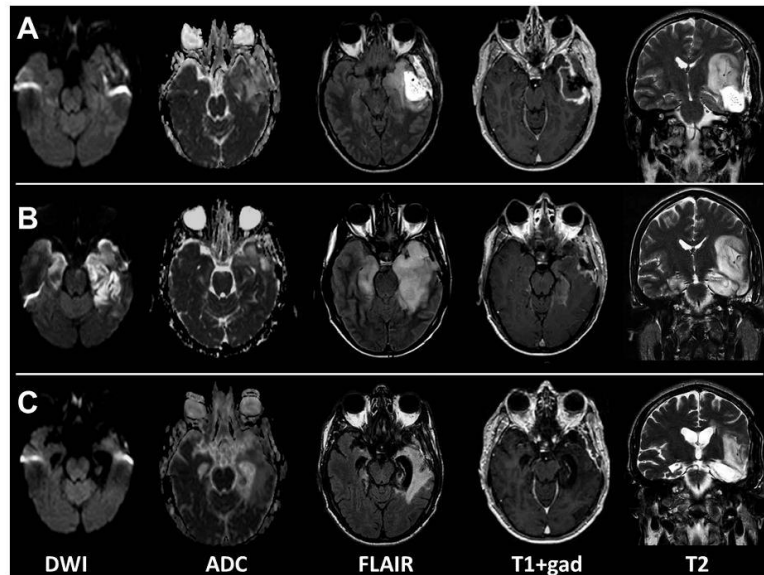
Patient 2 MRI pattern. (A) 22 days after surgical resection in the lateral left temporal lobe, with residual anaplastic astrocytoma in the left insula. (B) During acute herpes simplex encephalitis (HSE), involving bilateral temporomesial structures, more in the left hemisphere, where diffusion restriction and contrast enhancement is also more evident. (C) One year after the acute HSE: significant cerebral atrophy especially in bilateral temporomesial structures, where subtle abnormalities remain but no contrast enhancement. The residual anaplastic astrocytoma is stable.
